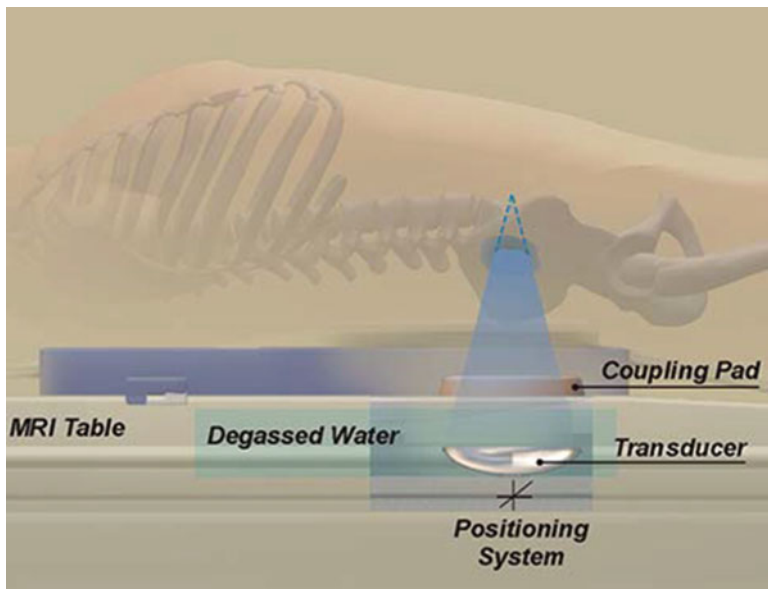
MRgFUS system showing the transducer and the positioning system and the ultrasonic energy converging at the focal point. The transducer is embedded in the patient table to facilitate the use of MRI [22]
